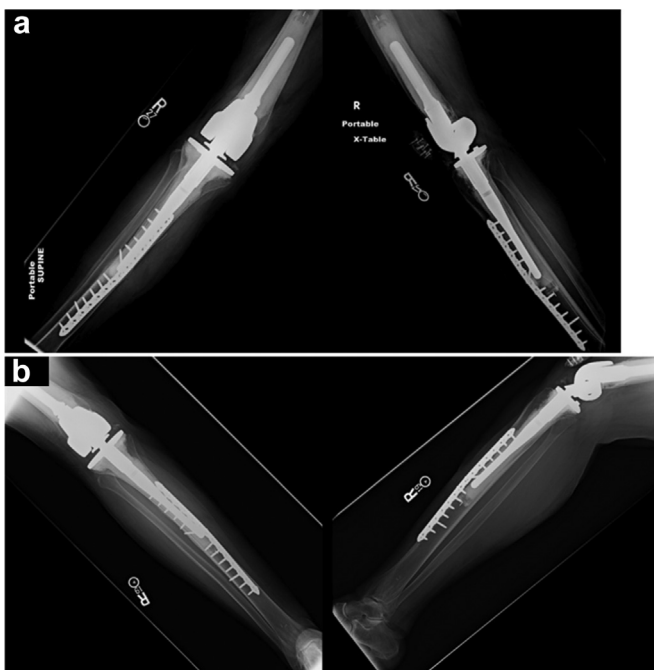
Post operative radiographs of right tibial reconstruction (a) showing tibial lesion filled with bone void filler and load-sharing bridge plate, and 2-year follow-up radiographs (b) showing density loss at the area of bone void filler. However, patient is pain free and customarily active.
